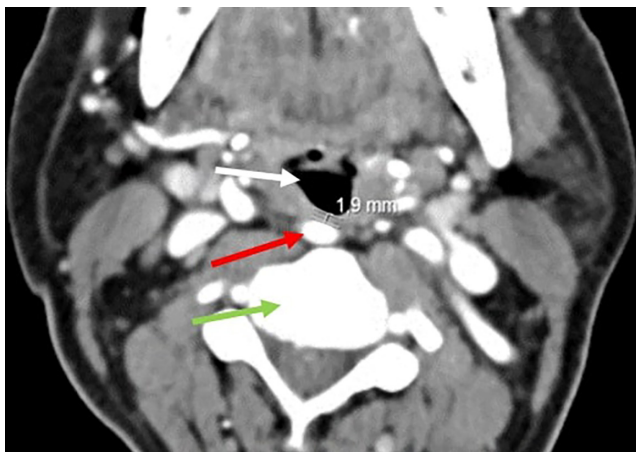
Cervicofacial CT scan, horizontal view; Minimum distance of 1.9 mm between the internal carotid artery (red arrow) and the posterior pharyngeal wall at the C3 vertebral level (green arrow). The hypopharyngeal space (white arrow) is compressed on the right by the carotid bulge.
